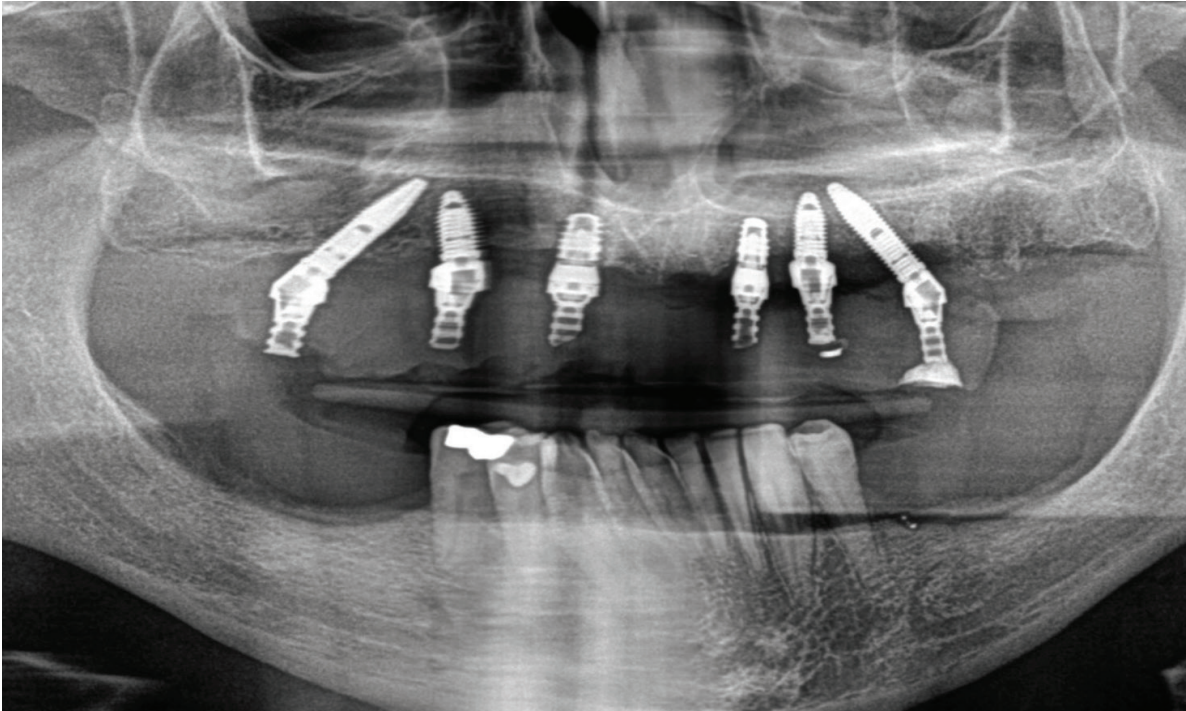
Radiography in the immediate postoperative period.
